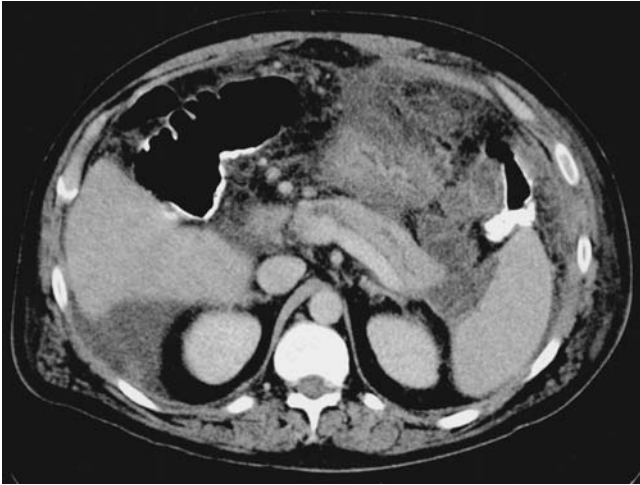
Contrast-enhanced abdominal CT scan in a 47-year-old man with acute pancreatitis. Relevant findings include significant fat stranding of the peripancreatic tissue, with a fluid collection at the tail of the pancreas measuring approximately 4×4 cm. Pancreatic parenchyma enhances with IV contrast, with no evidence of pancreatic necrosis. (Reproduced with permission from Clancy TE, Benoit EP, Ashley SW. Current management of acute pancreatitis. *J Gastrointest Surg.* 2005;Mar;9(3):440–452.)
